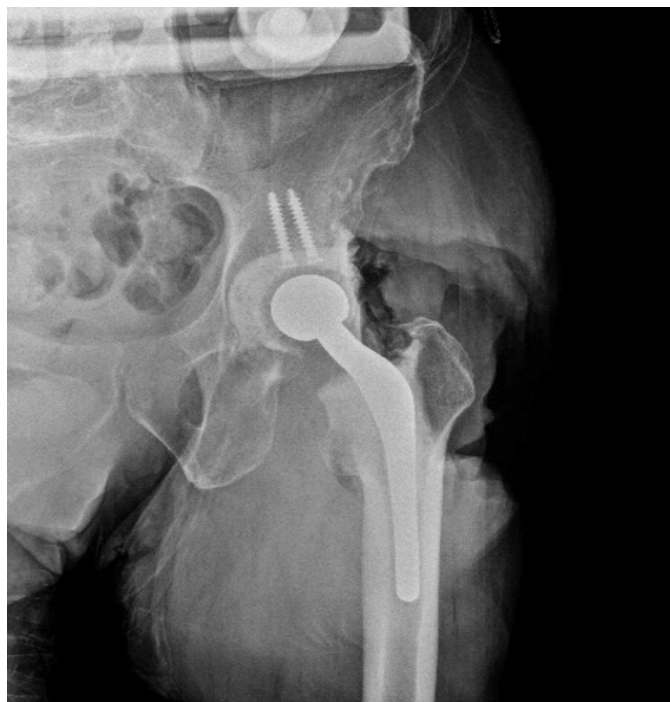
Intraoperative imaging of final spacer construct. Intraoperative AP radiograph of final spacer construct demonstrating stable alignment without fracture.
